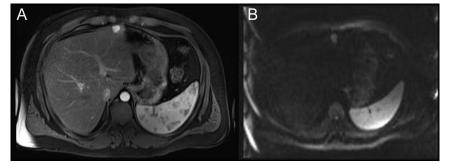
Abdominal magnetic resonance imaging showing (A) a 17 mm lesion in the left anterior hepatic lobe in the arterial phase and (B) a hyperintense left lobe lesion in the T2 phase.
